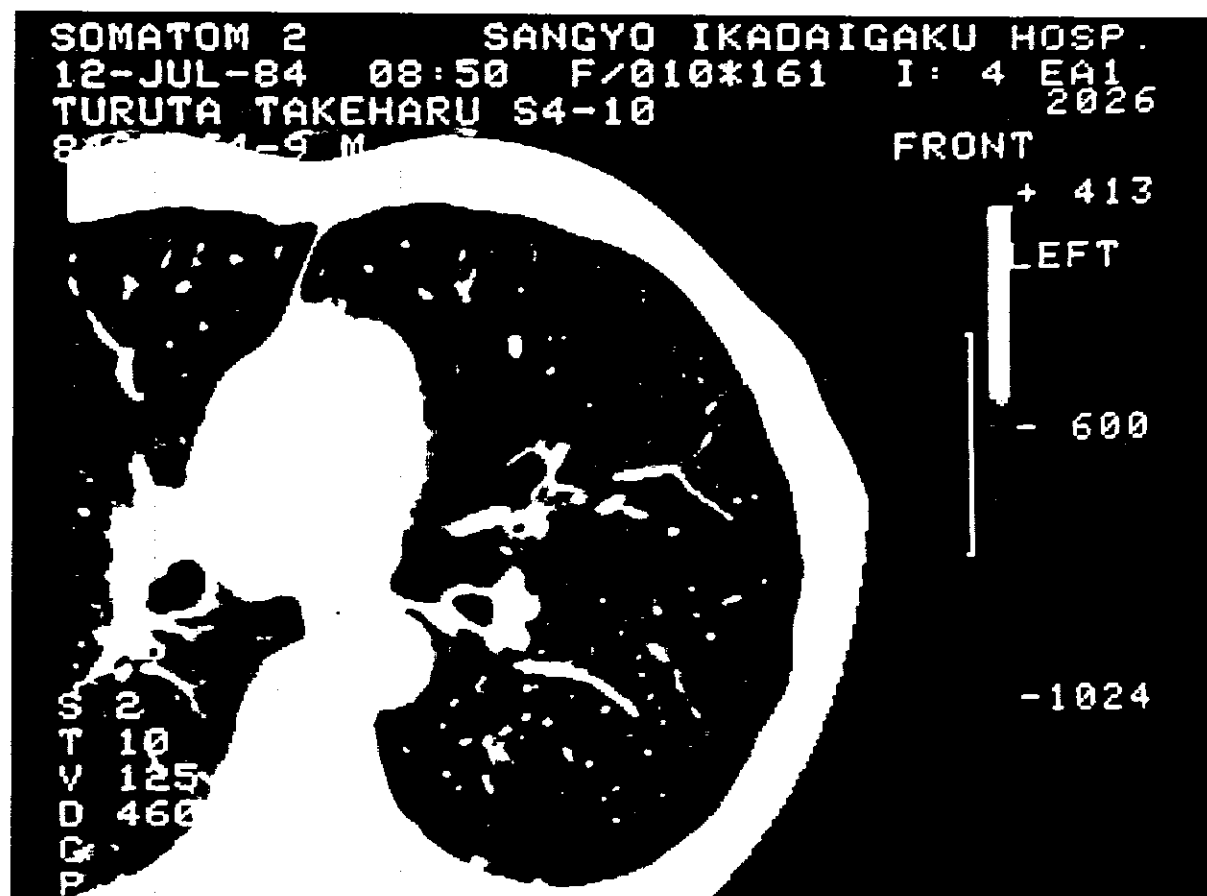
HRCT. Diffuse well-defined small opacities in the middle lung fields.
